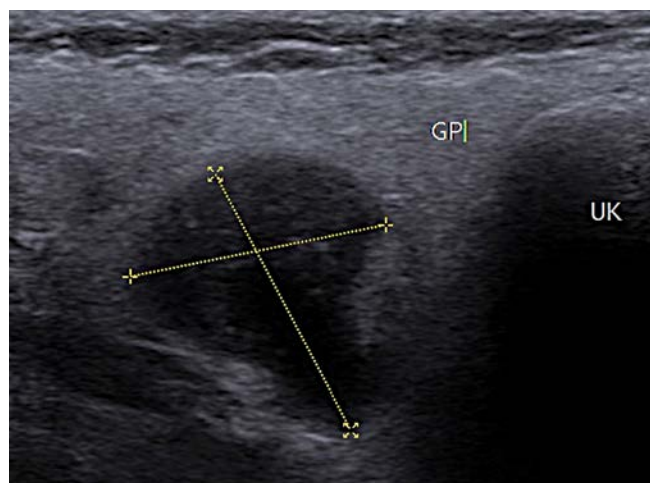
B-mode sonography of the first tumor in the caudal pole of the right parotid gland (1. case), GP – parotid gland, UK – mandible
